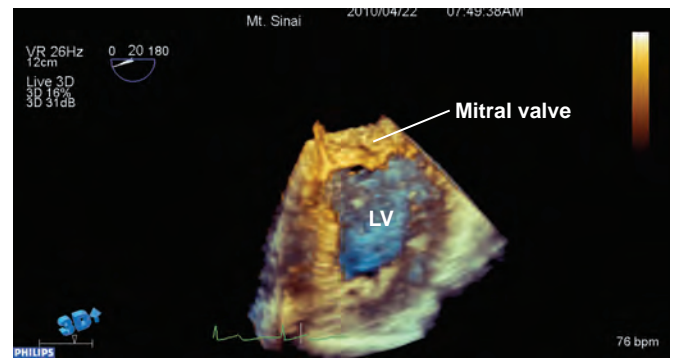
Live three-dimensional image of mitral valve and left ventricle (LV). Because of the matrix structure of the ultrasound transducer, this image represents a true live image. Change in transesophageal echocardiographic probe positioning by the echocardiographer results in instantaneous changes in the volumetric data set.
